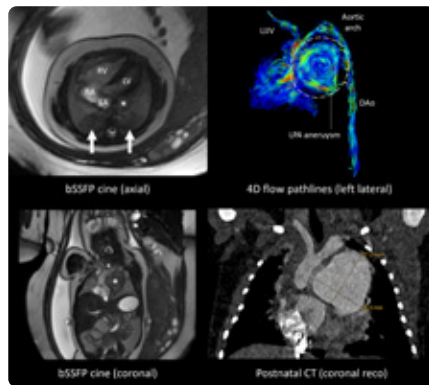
SbSSFP cine images reveal mesocardia/rightward shift of the heart, along with RV enlargement and hypertrophy. Characteristic of APVS, aneurysmal branch pulmonary arteries were observed, including a giant LPA aneurysm (asterisks), measuring 27 x 26 mm on postnatal CT, showing vortical flow at 4D flow pathline visualization. Prenatal axial cine MRI also revealed hypointense changes in both lower lung lobes, indicative of early pulmonary involvement (arrows).
